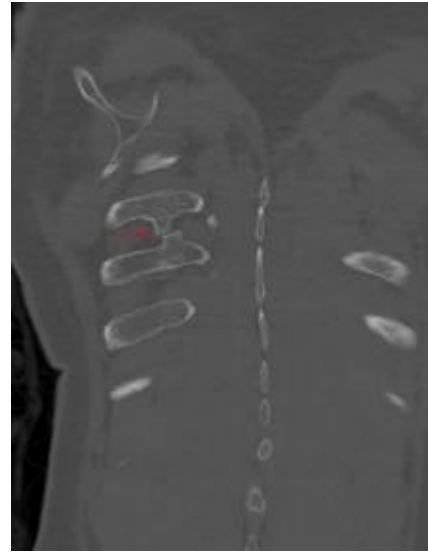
a. In the coronal CT image, exocytosis and pseudoarticulation are observed in the 7th and 8th ribs (red arrow).
